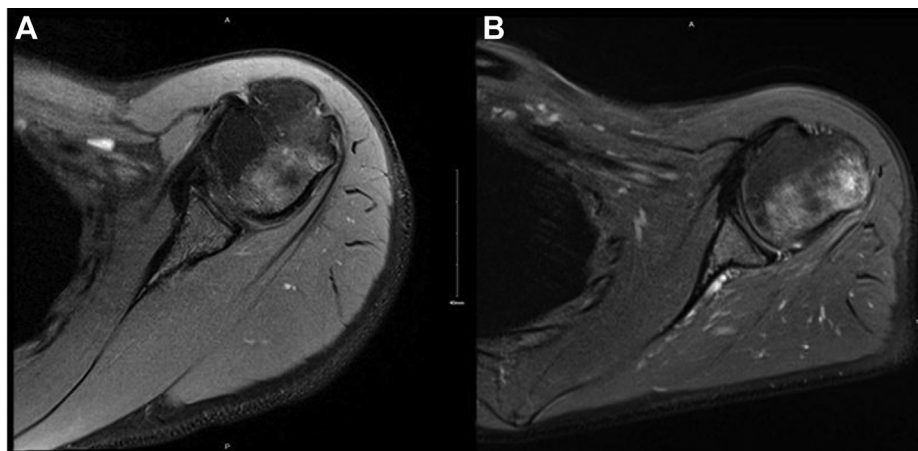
(A) MRI left shoulder, axial view T2 series obtained June 2018 demonstrating increased signal in the posterior aspect of the greater tuberosity with overall normal appearance of the overlying rotator cuff. (B) MRI left shoulder axial view obtained December 2018 (6 months later) demonstrating increased T2 signal in posterior greater tuberosity and involving the overlying rotator cuff and bursa. MRI, magnetic resonance imaging.
